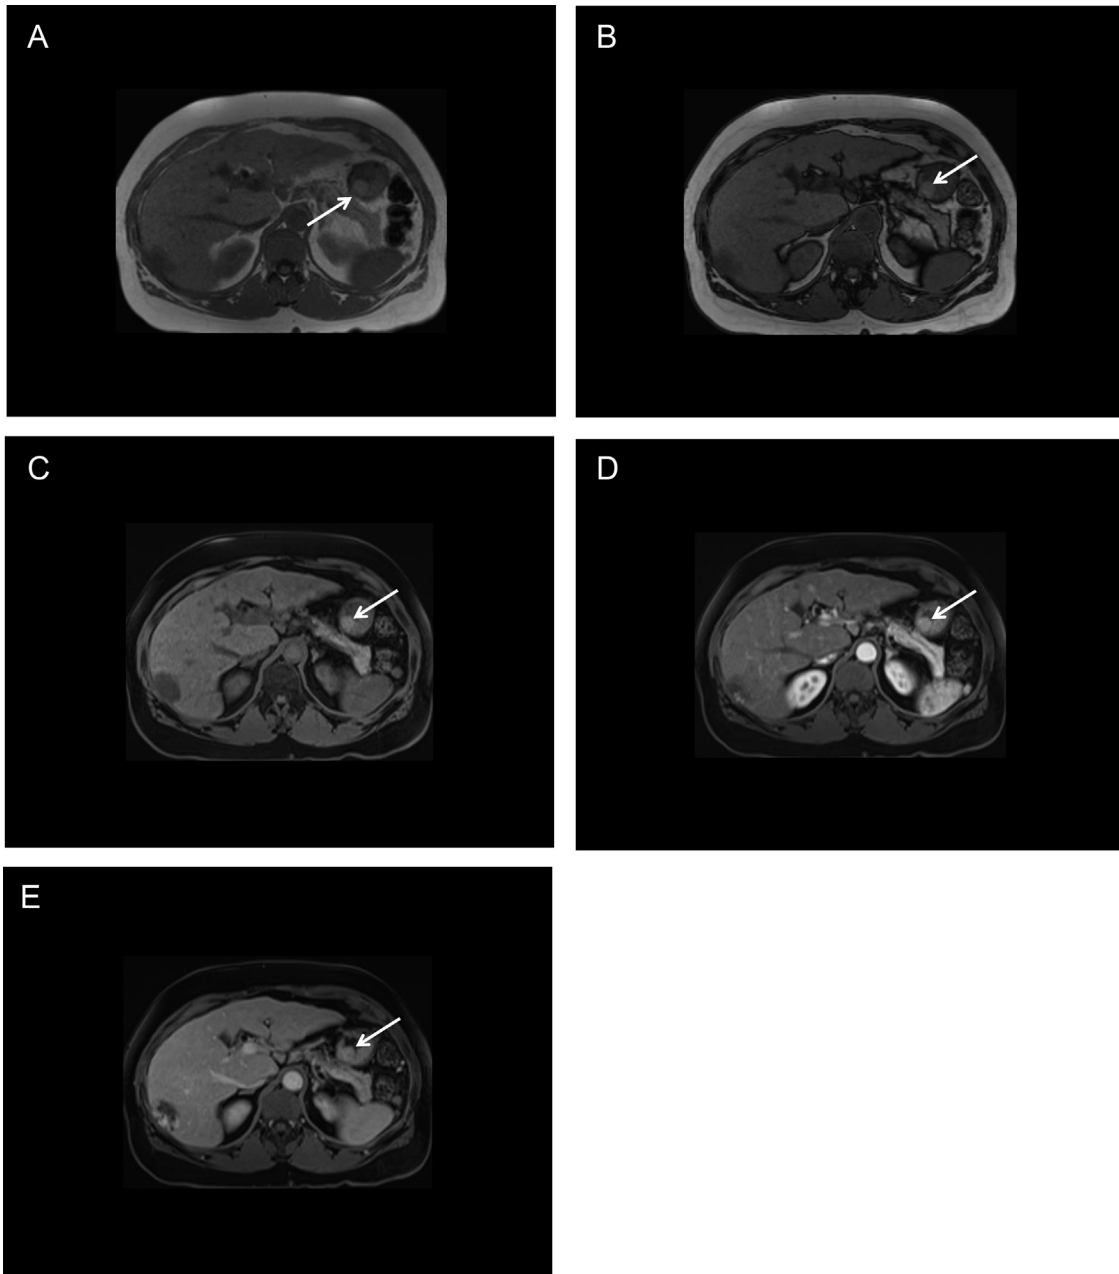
Gastric ectopic pancreas on magnetic resonance imaging (patient B). Magnetic resonance images: T1-weighted in-phase (A), T1-weighted out-of-phase (B), fat-suppressed T1-weighted precontrast (C) fat-suppressed T1-weighted postcontrast (arterial, D and venous, E) sequences in the axial plane showing a subepithelial nodule (arrow) which remains isointense to the normal pancreatic tissue in the precontrast sequences and enhances similarly after contrast administration. A liver hemangioma is depicted in segment VI.
